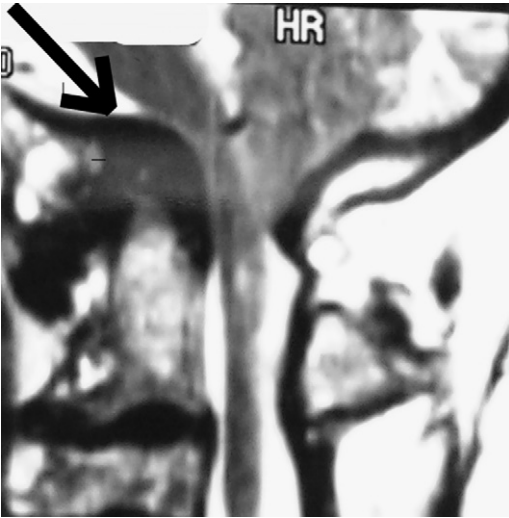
Sagittal T2-weighted MRI of a rheumatoid patient who has pannus (arrow) surrounding the dens.
